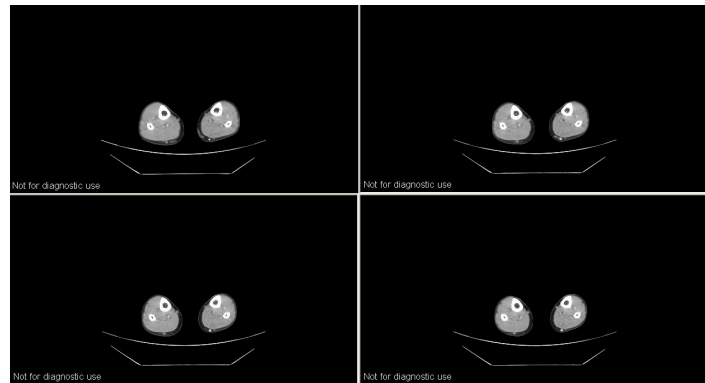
Fibula CT images
